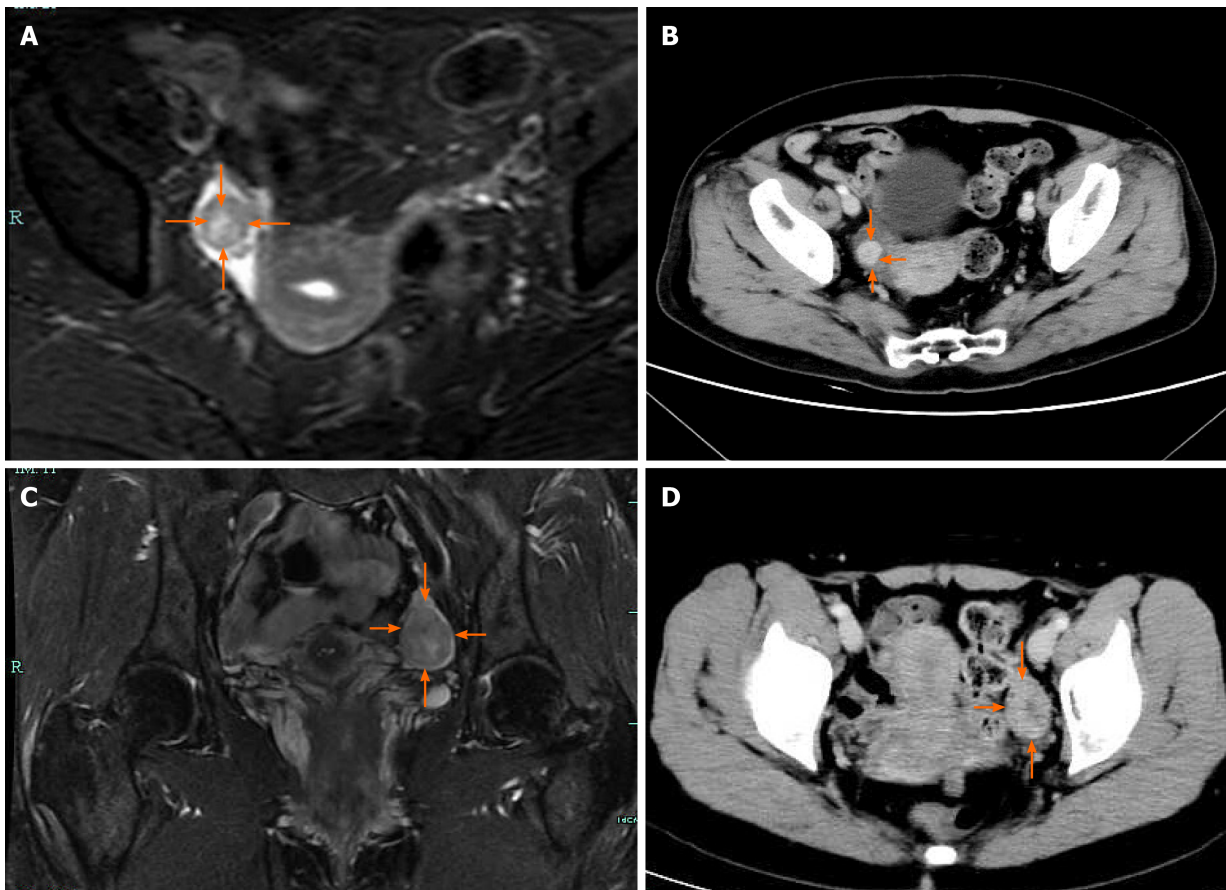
Enhanced magnetic resonance imaging (A and C) and computed tomography (B and D). A: Enhanced magnetic resonance imaging (MRI) of the pelvis showed nodules in the right adnexal area (case 1); B: Contrast computed tomography (CT) of the pelvis showed high-density shadows in the nodular tip of the right adnexal (case 1); C: Enhanced MRI of the pelvis revealed a space-occupying mass in the left adnexal area (case 2); D: Enhanced CT of the pelvis showed a solid/cystic mass in the left adnexal area (case 3).
